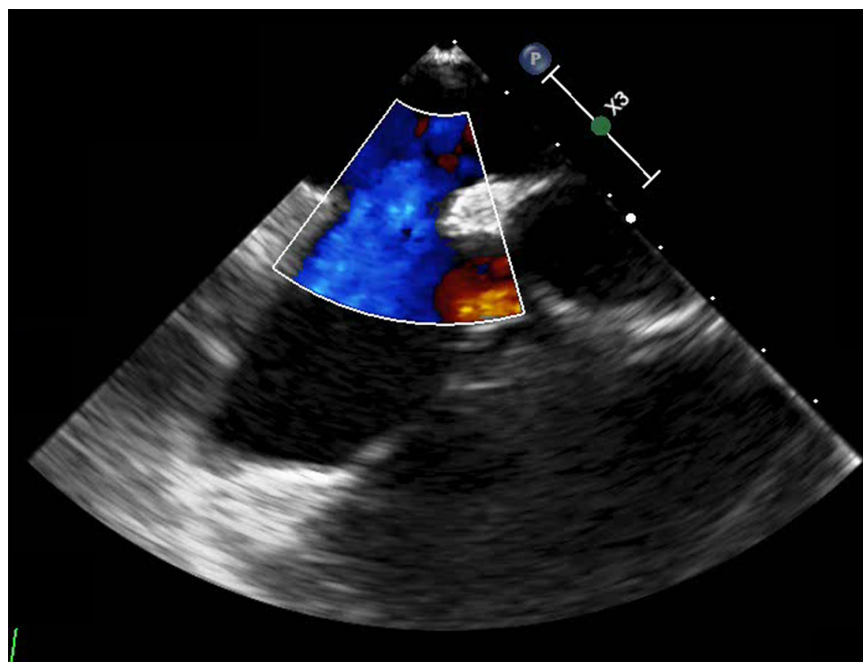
2D Doppler Echo demonstrating atrial septal defects left-to-right shunt
